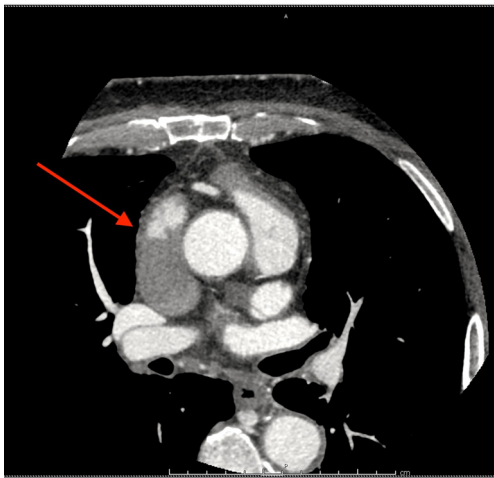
CT image of invasion and occlusion of superior vena cava extending up to the right atrium in a 72-year-old patient with malignant thymoma (red arrow). CT, computed tomography.
